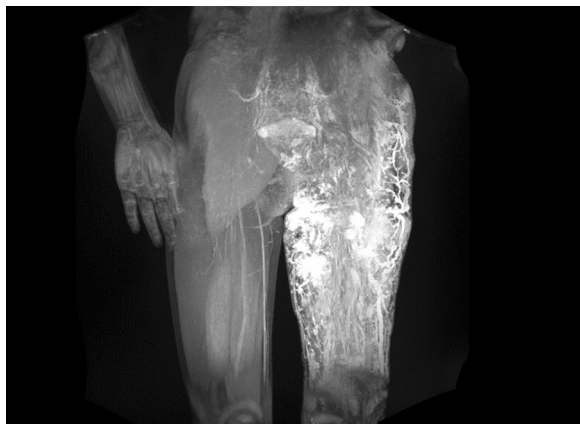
MRI scan of a vascular malformation
